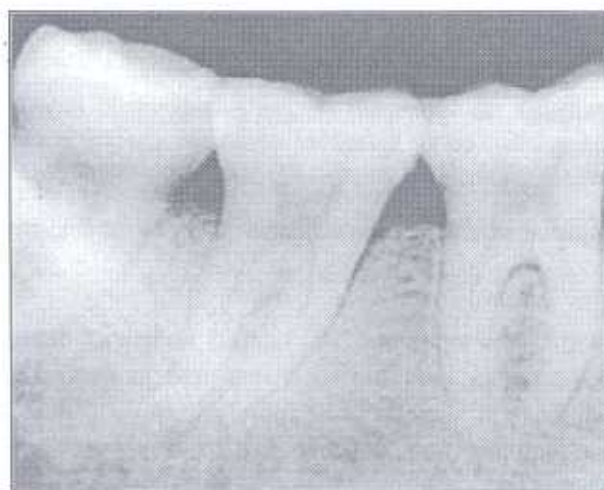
Original radiographic image, revealing sound molar teeth.
